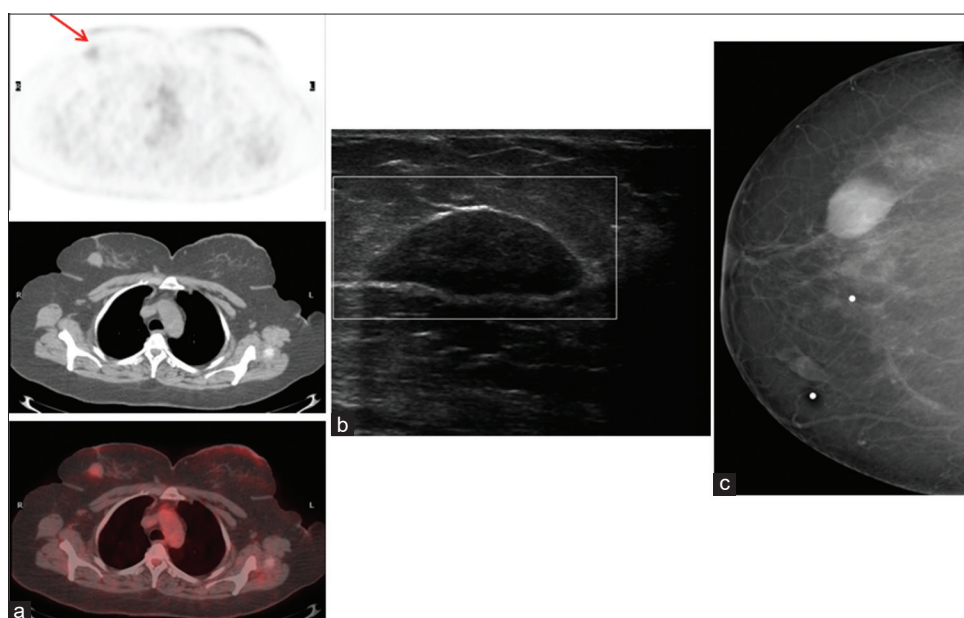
A 45-year-old female with a history of left breast carcinoma. Her staging positron emission tomography/computed tomography (a) revealing mild hypermetabolic mass in the right breast (red arrow), ultrasound (b) revealing a well-defined hypoechoic mass with pseudocapsule (2.7 cm × 1.1 cm × 2.5 cm) with no vascularity suggestive of benign etiology/fibroadenoma. Her mammogram (c) revealing a well-defined mass in the left upper quadrant suggestive of benign etiology
